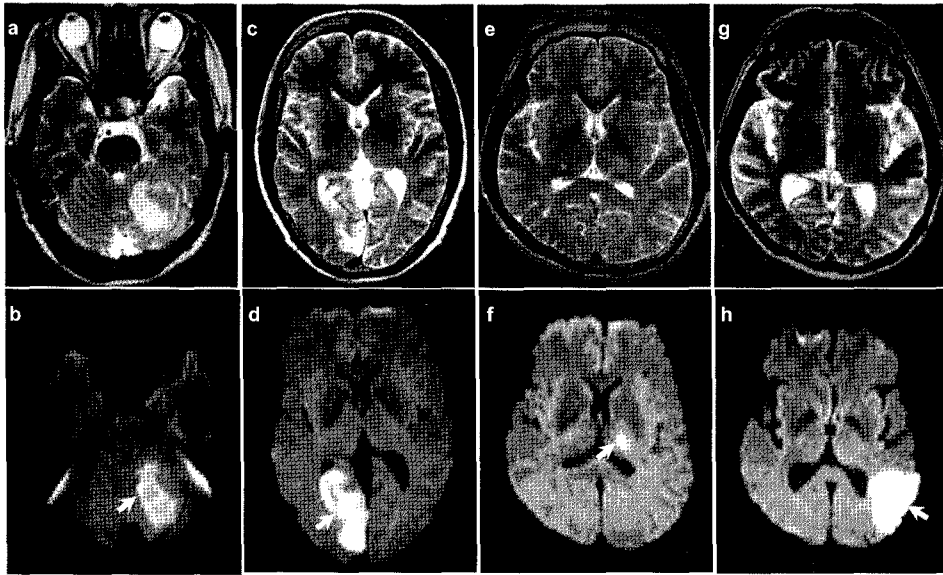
Axial T2-weighted MR images (upper) and diffusion weighted images (lower) from patients with acute infarction. In a 52-year-old woman (a and b) within six hours of the onset of the infarction, T2WI and DWI show the infarcted region in the left cerebellum. In a 63-year-old woman (c and d) within 20 hours of the onset of the infarction, T2WI and DWI show the infarcted region in the right calcarine gyrus. However, in a 46-year-old man (e and f) within six hours and in a 63-year-old man (g and h) within nine hours of the onset of the infarction, only DWI discriminates the infarcted region in the left thalamus and in the left parietal gyrus.
